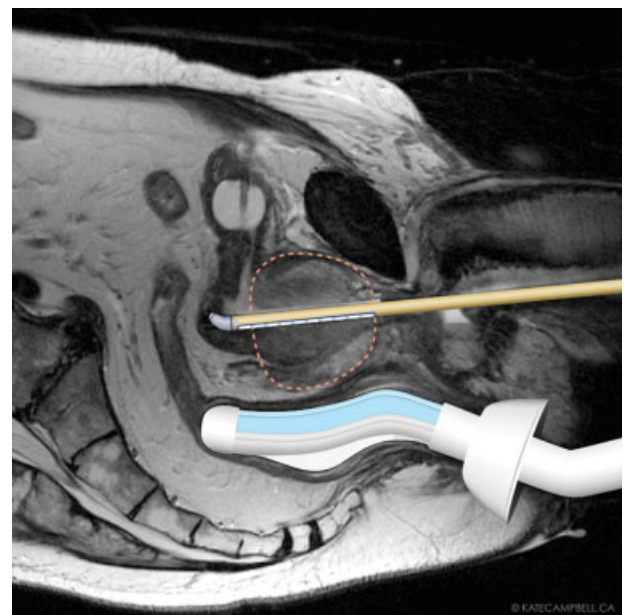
Representative sagittal MRI image demonstrating placement of the transurethral ultrasound applicator and the endorectal-cooling device which are a part of the TULSA-PRO system. (Image used with permission from Profound Inc.)
